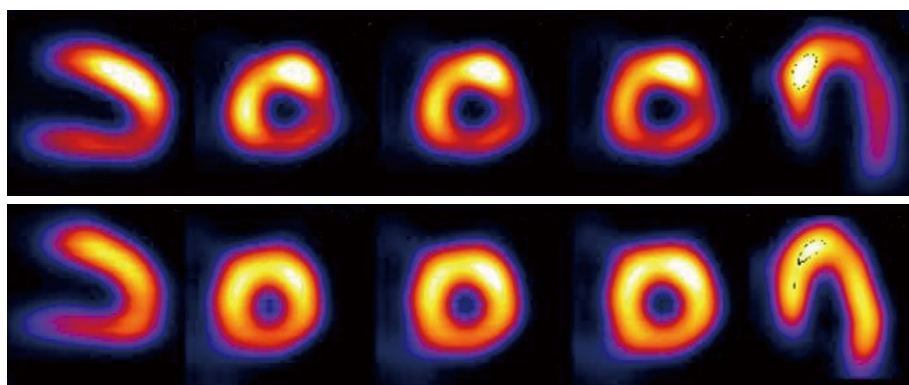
Single photon emission computed tomography image of exercise ^{201}Tl scintigraphy in a 70-year-old man. The stress image (upper panel) shows decreased perfusion in the infero-lateral region. There is a redistribution of the tracer in the rest image (lower panel), which indicates exercise-induced myocardial ischemia in the infero-lateral region of the left ventricle.
